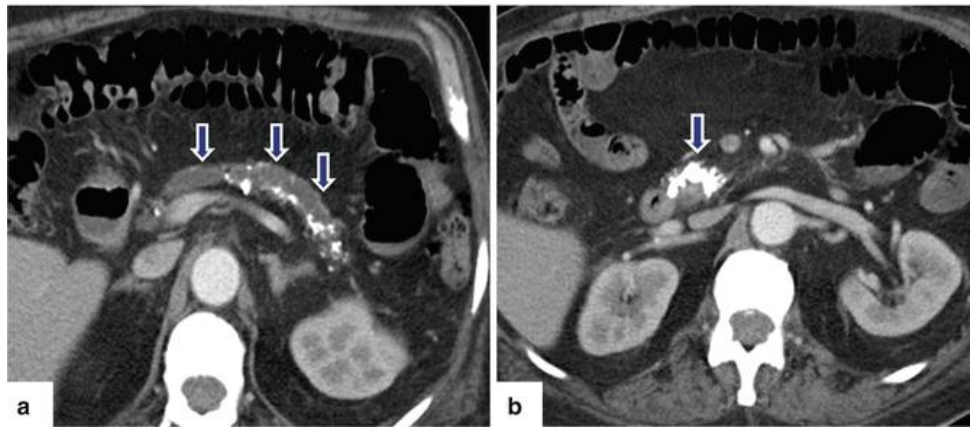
Chronic pancreatitis on CT: A 73-year-old with history of alcohol abuse. CECT axial images (a, b) reveal a prominent dilated main pancreatic duct (arrows), marked parenchymal atrophy, and multiple calcifications in the pancreas [31]
